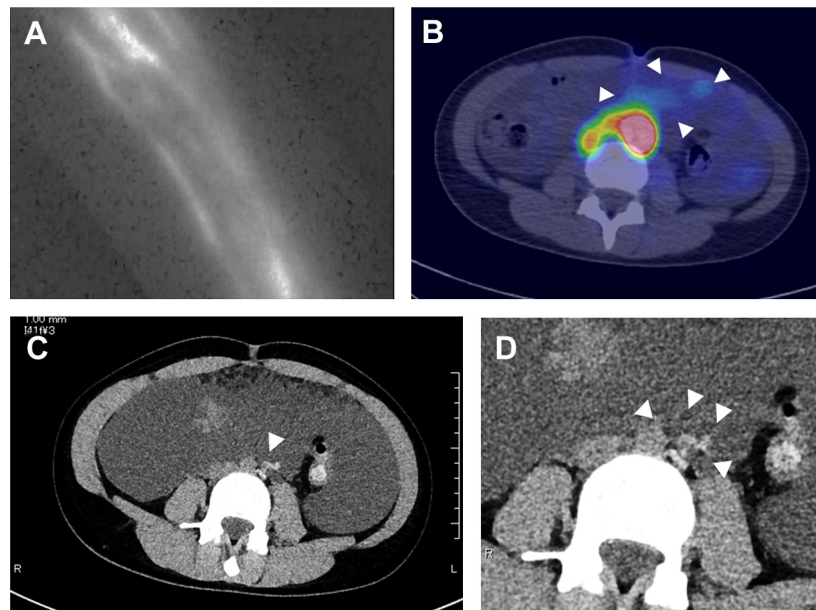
A, Indocyanine green (ICG) lymphography with a photodynamic eye camera. The left lower limb of the patient shows smooth lymphatic flow and no obvious dermal backflow. B, Lymphoscintigraphy combined with computed tomography (CT) demonstrates chyle leakage (*arrowheads*). C and D, CT-lymphangiography by the direct injection of water-soluble contrast medium into a lymphatic vessel of the lower limb; *arrowheads* show the extravasation of contrast medium from the left lumbar lymphatic trunk at the level of the umbilicus.
